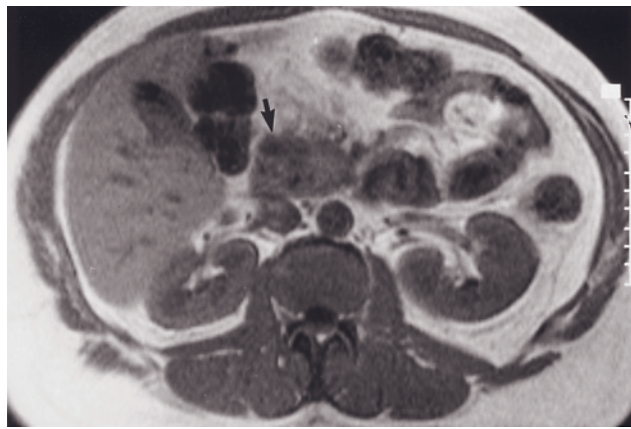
(Continued) T2-weighted SS-ETSE, T1-weighted SGE (*f*), T1-weighted fat-suppressed SGE (*g*), and immediate (*h*) and 45-s (*i*) postgadolinium T1-weighted SGE and 90-s postgadolinium fat-suppressed SGE (*j*) images in a second patient with moderately differentiated adenocarcinoma. There is a 1.5-cm mass arising in the lateral aspect of the pancreatic head, which invades the duodenal wall and causes biliary ductal dilatation. On the T2-weighted images (*d*, *e*), CBD obstruction is well shown, but the tumor itself is almost imperceptible. The tumor (arrow, *g*) is most clearly appreciated on the noncontrast T1-weighted fat-suppressed SGE image (*g*) and the immediate postgadolinium SGE image (*h*). Progressive tumor enhancement and pancreatic parenchyma wash-out over time (*i*, *j*) diminishes the tumor-pancreas contrast, which is most problematic with small tumors. The gastroduodenal artery (arrow, *h*) is well shown on the immediate postgadolinium image as an enhancing structure. The tumor is shown to abut this vessel. Approximately one-quarter of all pancreas head cancers exhibit some degree of duodenal wall invasion.
